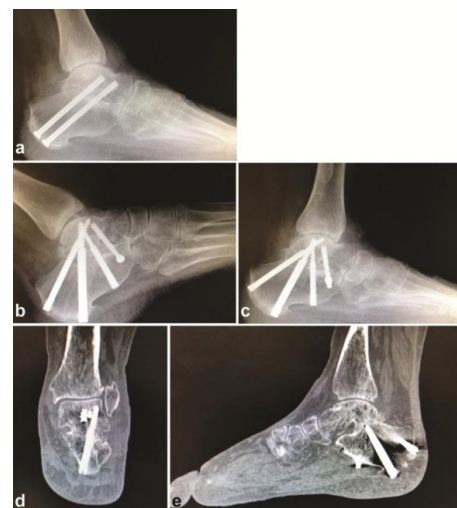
Case #9, a 50-year-old female with diabetes, neuropathy, and hypertension, who had previously undergone subtalar arthrodesis of the left foot. (A) Preoperative lateral radiograph indicates nonunion of the subtalar joint. The patient underwent revision subtalar joint fusion with new hardware and rhPDGF-BB/ $\beta$ -TCP. Postoperative radiographs at (B) 6 weeks and (C) 14 weeks, and (D, E) CT scans at 10 weeks demonstrate fusion of the subtalar joint.
